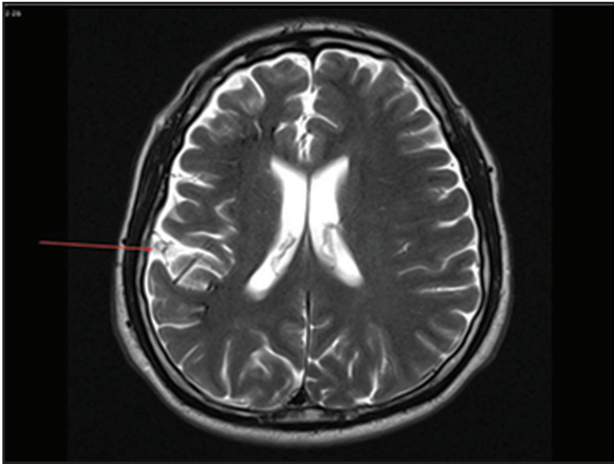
Axial T2-weighted MRI demonstrating focal encephalomalacic and gliotic changes adjacent to the right parietal calcified lesion with associated cortical volume loss (red arrow).
